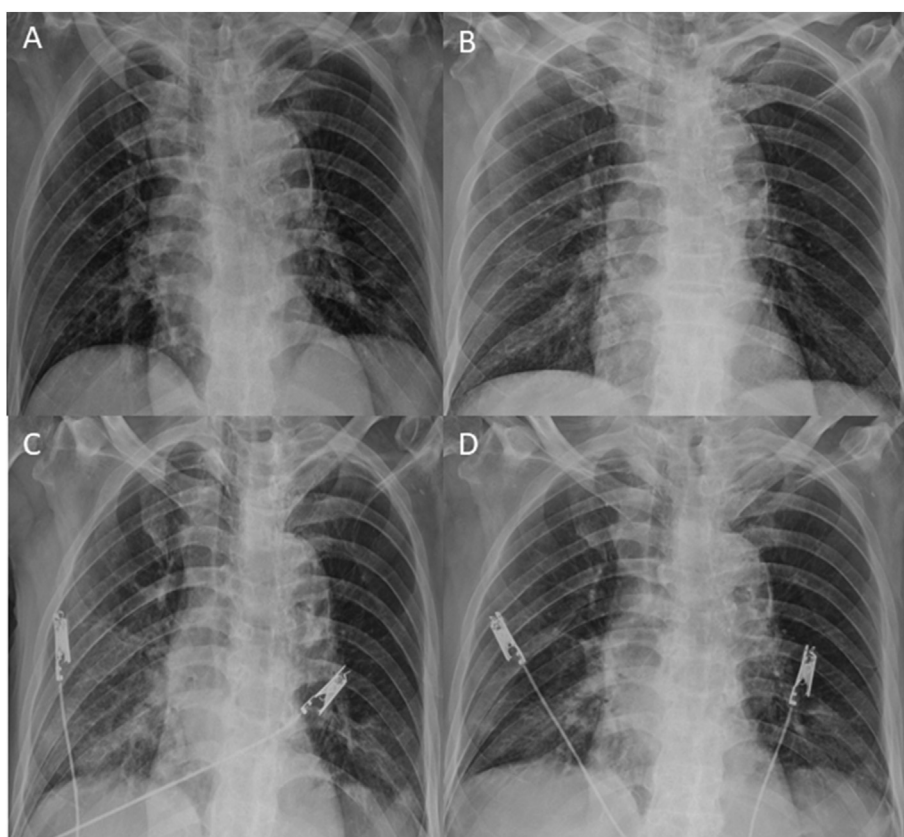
Chest X-rays of another patient with pneumonia on days 1 (A), 5 (B), 10 (C), and 14 (D) after admission.
